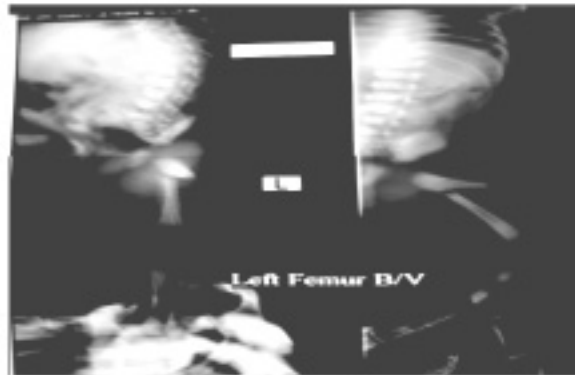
X-ray showing fracture femur
